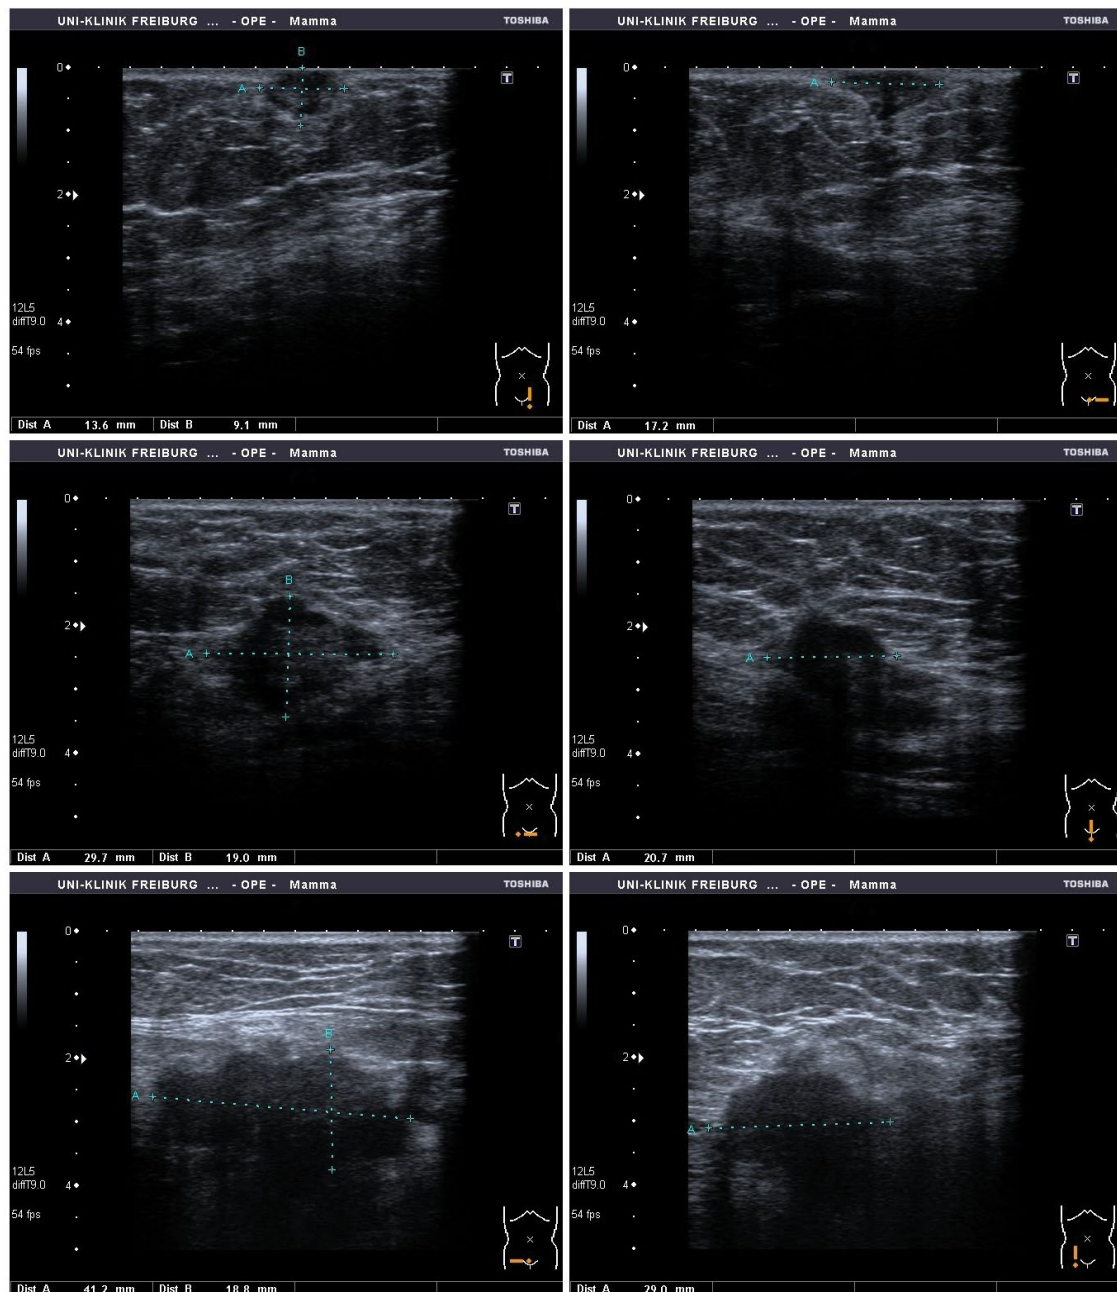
Ultrasonography (2D, Aplio 500, 13 MHz (Toshiba™)): 3 cases of AWE in the subcutaneous tissue layer at Pfannenstiel incision after caesarean section. Top: AWE in the subcutis, middle and bottom: AWE in the fascia of the M. rectus abdominis.
